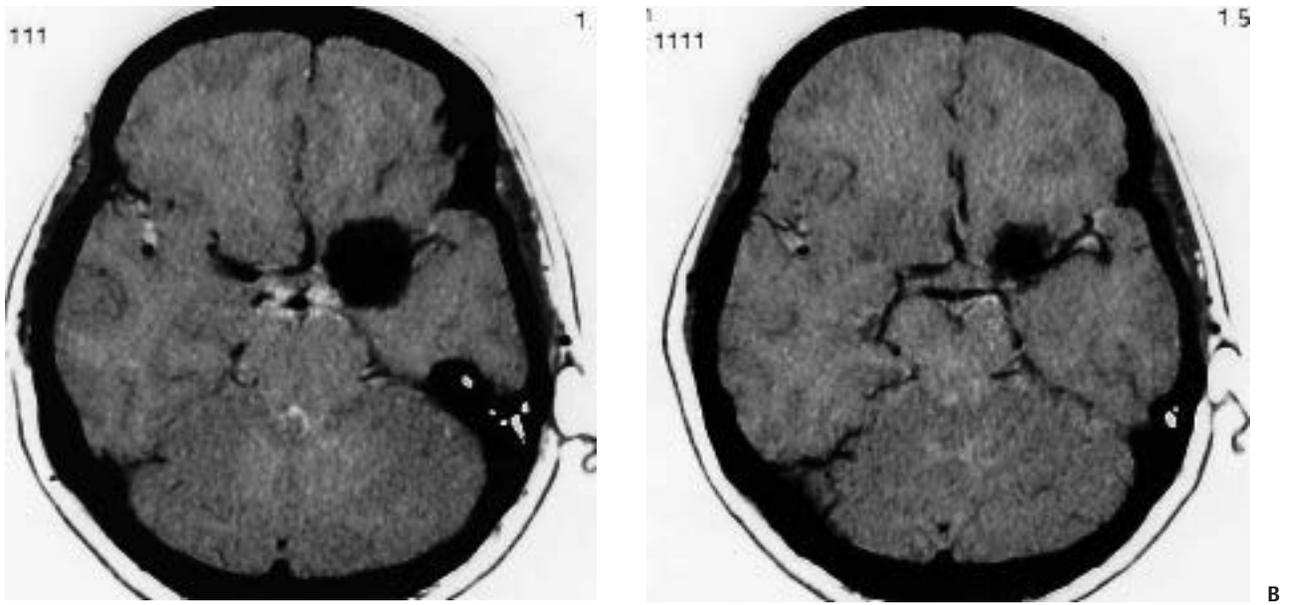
(A,B) Axial computed tomographic scans of a typical clinoidal meningioma.
